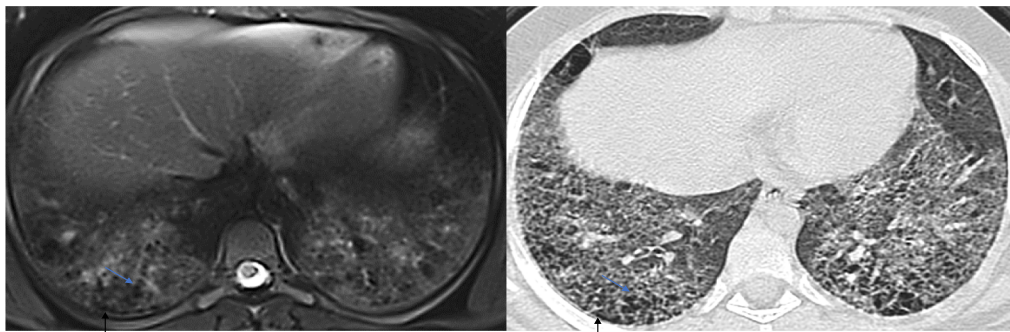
A 10-year-old female diagnosed as interstitial pulmonary fibrosis (usual interstitial pneumonia), T2 blade, and comparable HRCT cut; both show bilateral fairly symmetrical basal reticulations, interlobular septal thickening, traction bronchiolectasis (blue arrows), bronchial wall thickening, and honeycombing (black arrows). CT score 18, MRI score 20
